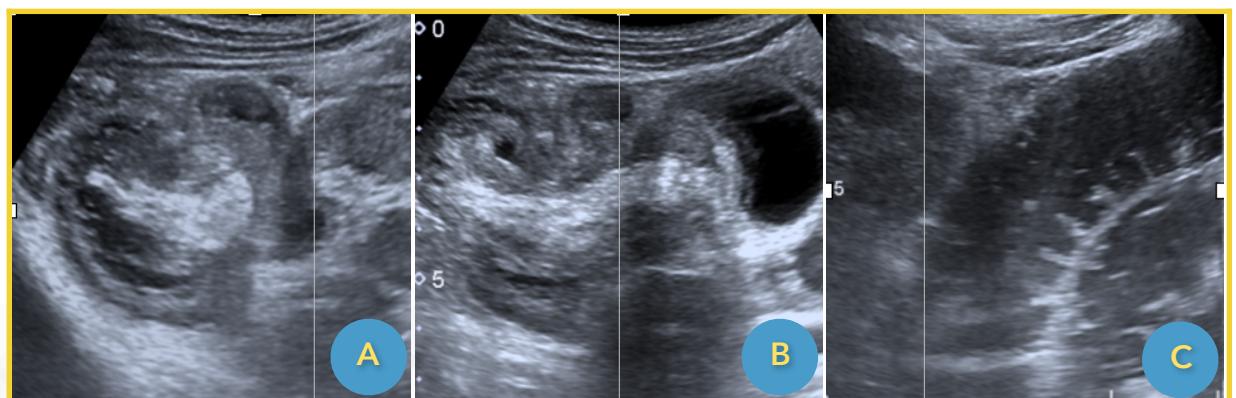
Ultrasonography Findings of Case 1.
